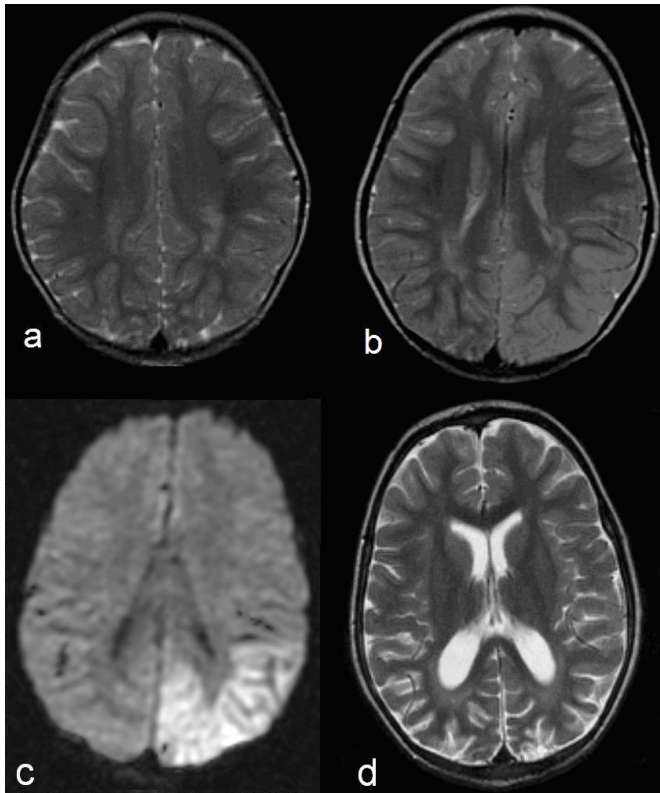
Patient AS-1 with Alpers syndrome due to POLG1 mutations: This patient had a normal axial T2-weighted image at 1.5 years of age (a). Follow-up MRI at 3 years of age showed a swollen left occipital cortex on T2-weighted image (b) with decreased diffusion (c). Follow-up MRI at 3.5 years of age showed atrophy of the occipital cortex at T2-weighted image (d).
